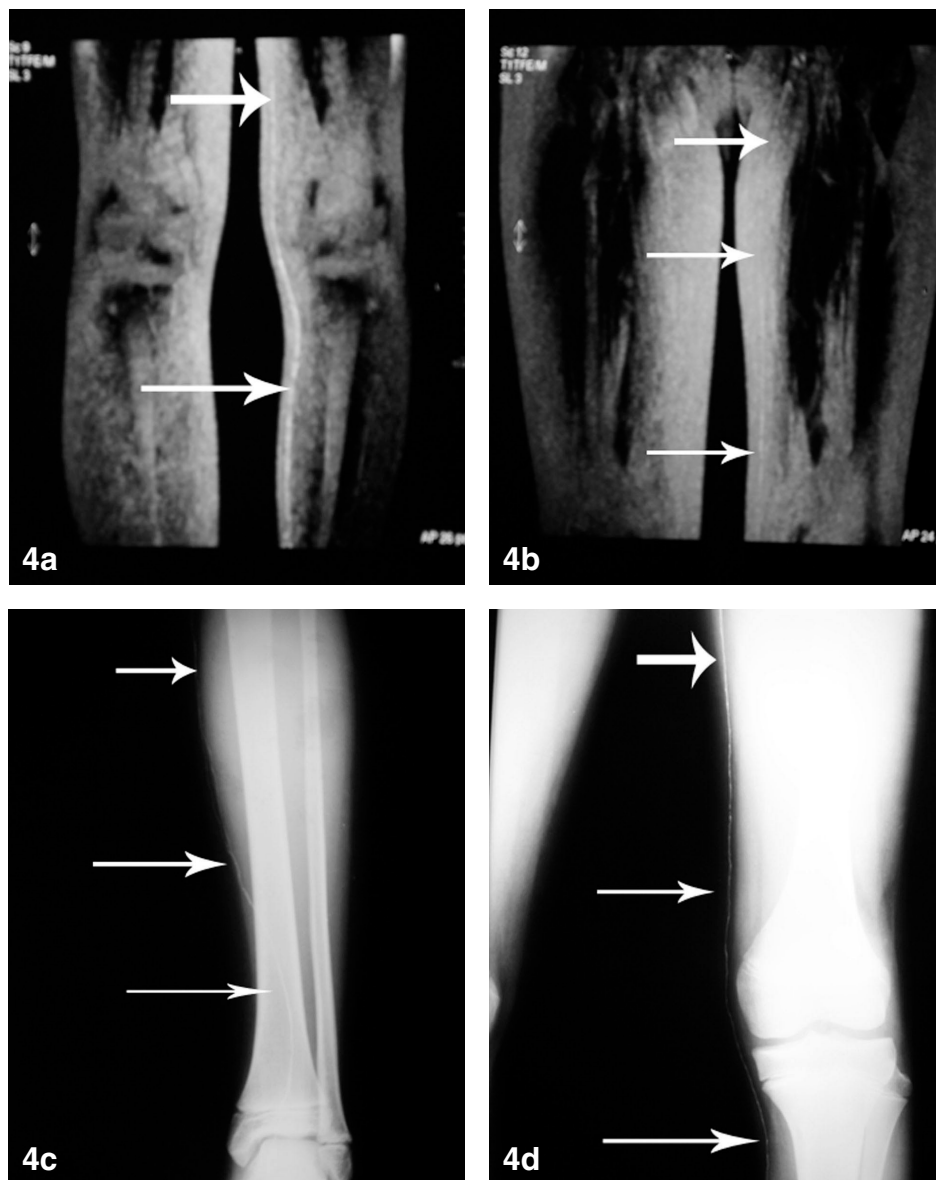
Depiction of a single lymphatic vessel (white arrows) in IMPRL (a,b) which was confirmed by direct x-ray lymphography (c,d) in a subject with lymphedema (No 10. from Table 1).
